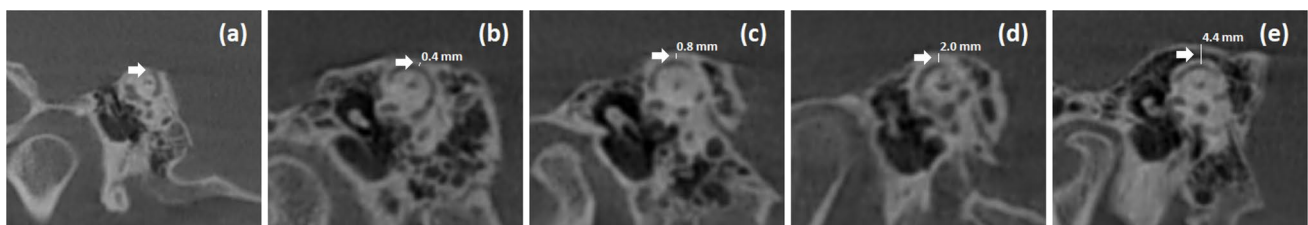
Radiological patterns of SSCs with reformatted cone beam computed tomography images. a Dehiscent pattern, b papyraceous pattern, c normal pattern, d thick pattern, e pneumatized pattern
